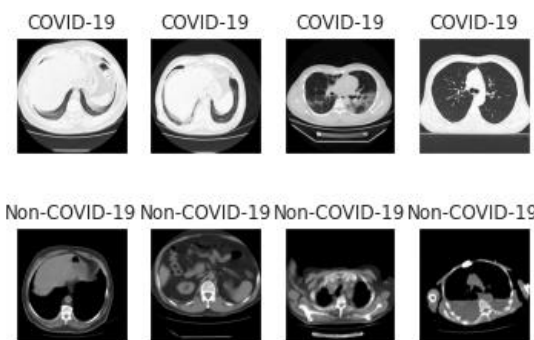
Random images from CT scan dataset
